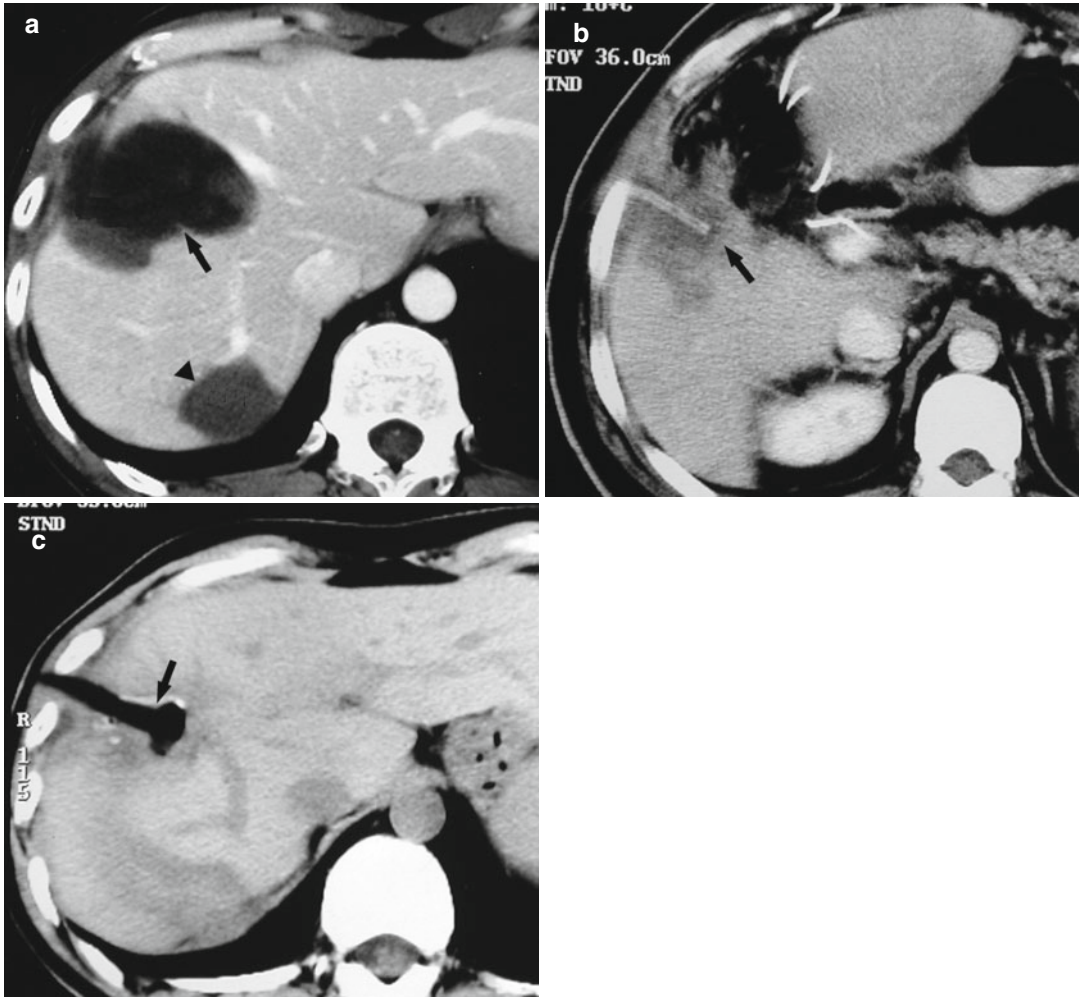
Biloma in a 62-year-old man with liver metastatic nasopharyngeal carcinoma (3.9×4.1 cm in size) (Picture Credits: Liang et al. [2]. Copyright holder: 2009 Radiological Society of North America). (a) Contrast CT obtained 1 month after microwave ablation (MWA) showed biloma represented by an area of fluid-filled
